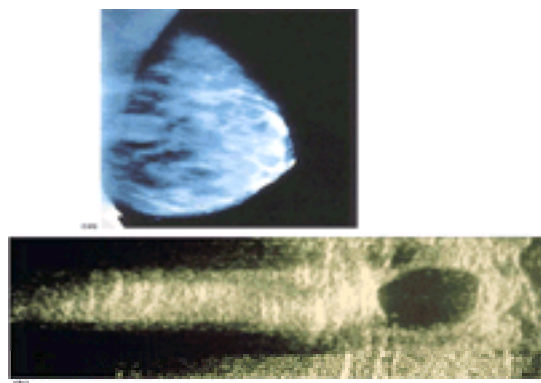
(a) Breast cyst on mammography: note the well-delineated, homogeneous opacity; (b) breast cyst on ultrasonogram: note the well-delineated- homogeneous opacity (by courtesy of Dr B. Shepstone).
